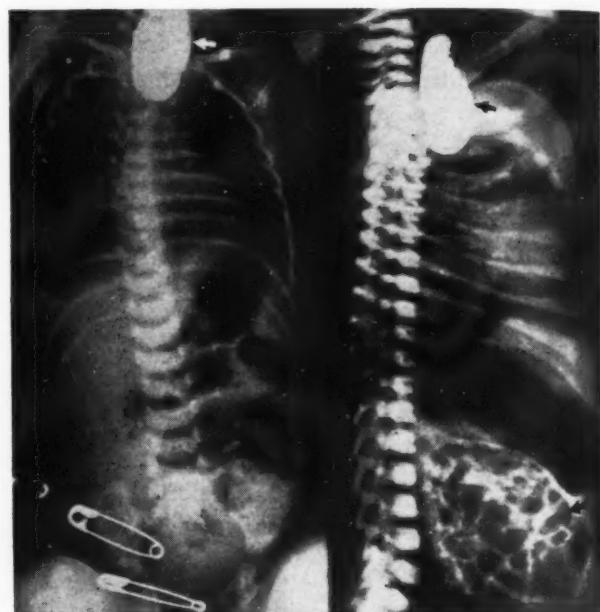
Radiographs of a day old infant, anterior-posterior and lateral views. Esophageal atresia and tracheoesophageal fistula. Arrows at top of films point to the blind esophageal pouch. The arrow in the lower part of the film, of the lateral view, points to air in stomach and small bowel.
